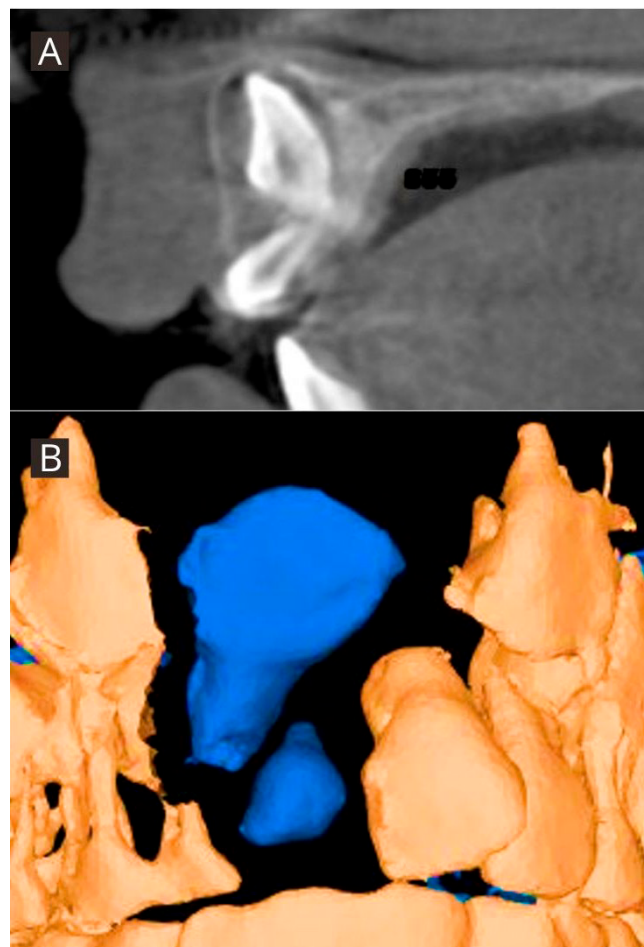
Tomographic images. A. The initial sagittal section of tooth 11 was evaluated in CBCT. B. Three-dimensional representation of initial position of tooth 11 evaluated on CBCT, frontal view.
